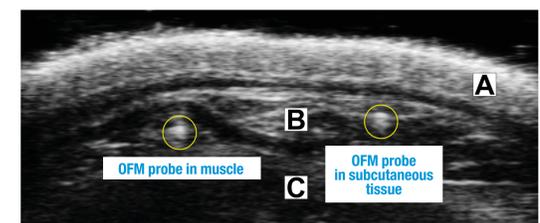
Ultrasonic image of the interscapular area. A- dermis, B- subcutis, C- muscle. The verification whether subcutaneous BAT or WAT was penetrated is done post mortem via dissection
